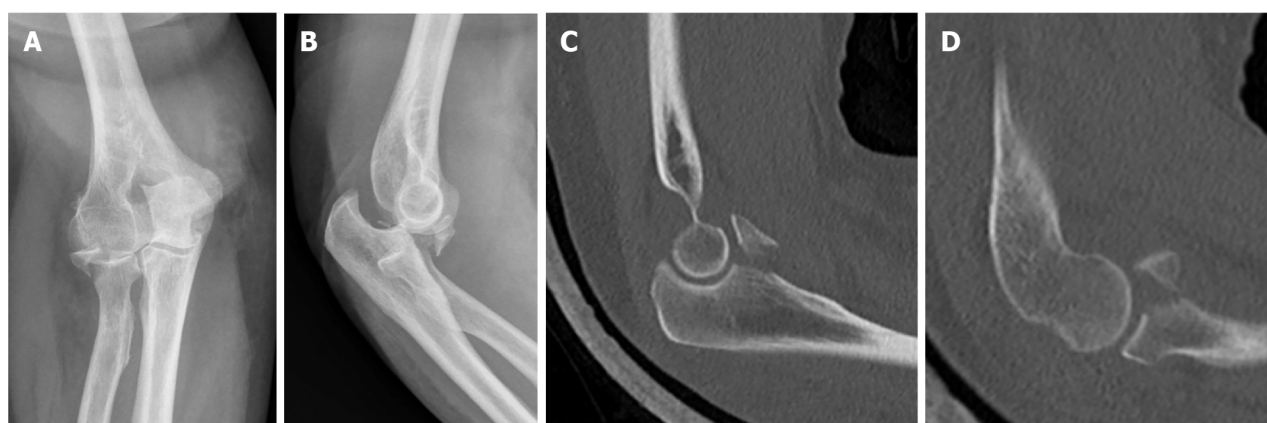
Injury films on presentation depicting a terrible triad fracture. A-D: Anterior posterior (A) and lateral (B) radiographs, sagittal computer tomography cuts showing coronoid fracture (C) and radial head fracture (D).
